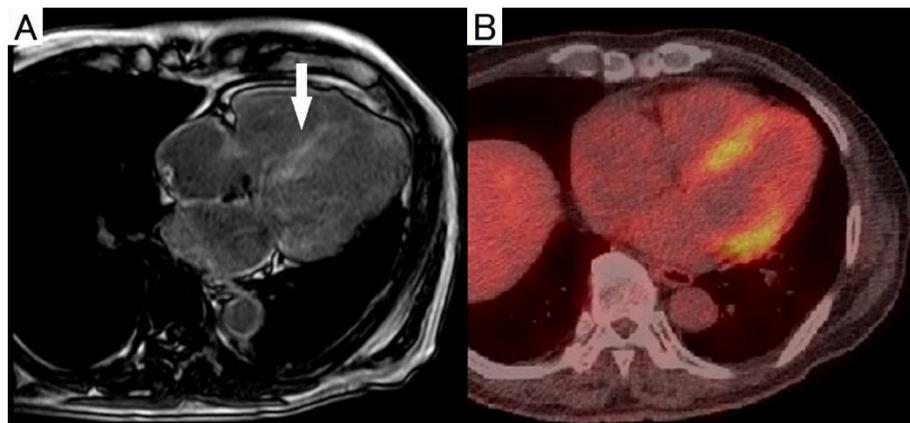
Widespread subendocardial and partly transmural enhancement of the left ventricular myocardium was detected in delayed postcontrast T1-weighted images (A) (arrow). ^{18}F -FDG PET/CT revealed tracer uptake ($\text{SUV}_{\text{max}}=6.2$) in the left ventricle wall (B)
